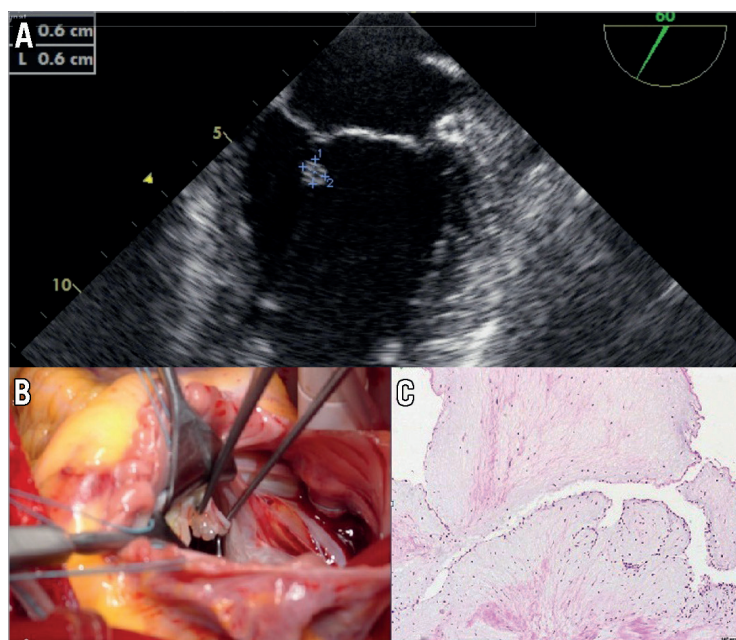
A) Transthoracic image showing a mobile mass of the mitral valve chordae. B) Operative view of the tumour of the primary chordae of the mitral A2 scallop. C) Macroscopic view of the tumour which shows papillary projections.
